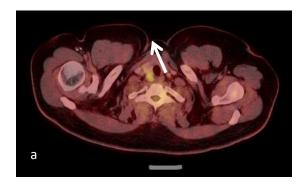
a-b coronal and sagittal PET/CT images show negative study for metabollicaly active FDG avid tumoral residue versus recurrence at the superior mediastinum, Note the the multiple focal FDG avid accumulation seen at the cervical and supraclavicular regions more noted at the left side consistent with normal variant brown adipose tissue FDG uptake (arrows)
